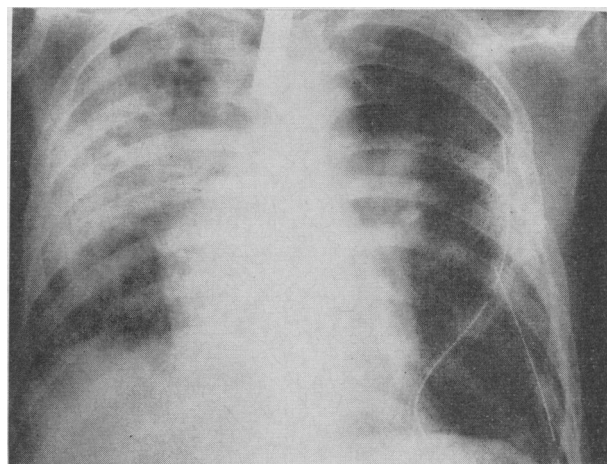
Chest radiograph of recipient three days post transplantation.
